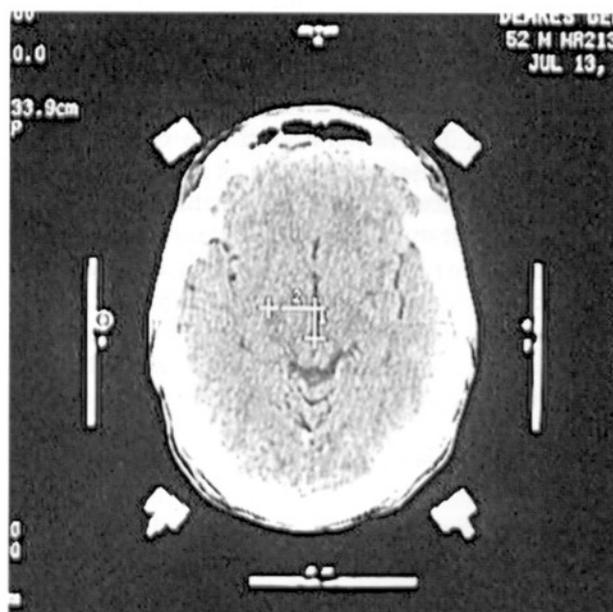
Fig 2: An axial CT scan at the level of anterior and posterior commissures demonstrates the thalamic target point with respect to posterior commissure.
